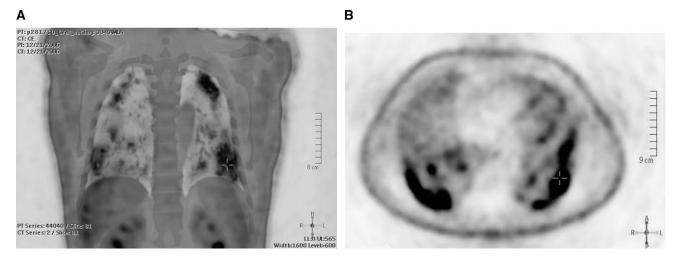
Initial positron emission tomography–computed tomography for the patient, showing exclusive uptake on the lung lesions A, Frontal section. B, Transverse section.
